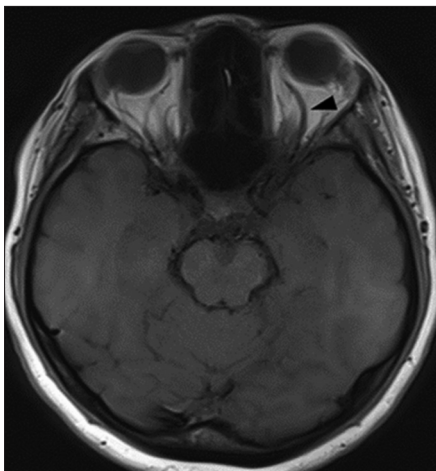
Axial T1-weighted magnetic resonance imaging of the brain shows an enlarged left superior ophthalmic vein (arrowhead)
